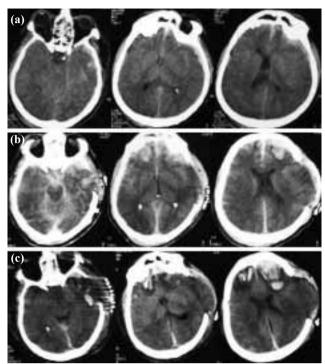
Preoperative (a), 24-hour (b) and one-week (c) CT scans obtained in a 32-year-old male with TBI undergoing early unilateral decompressive craniectomy as the primary therapy.
